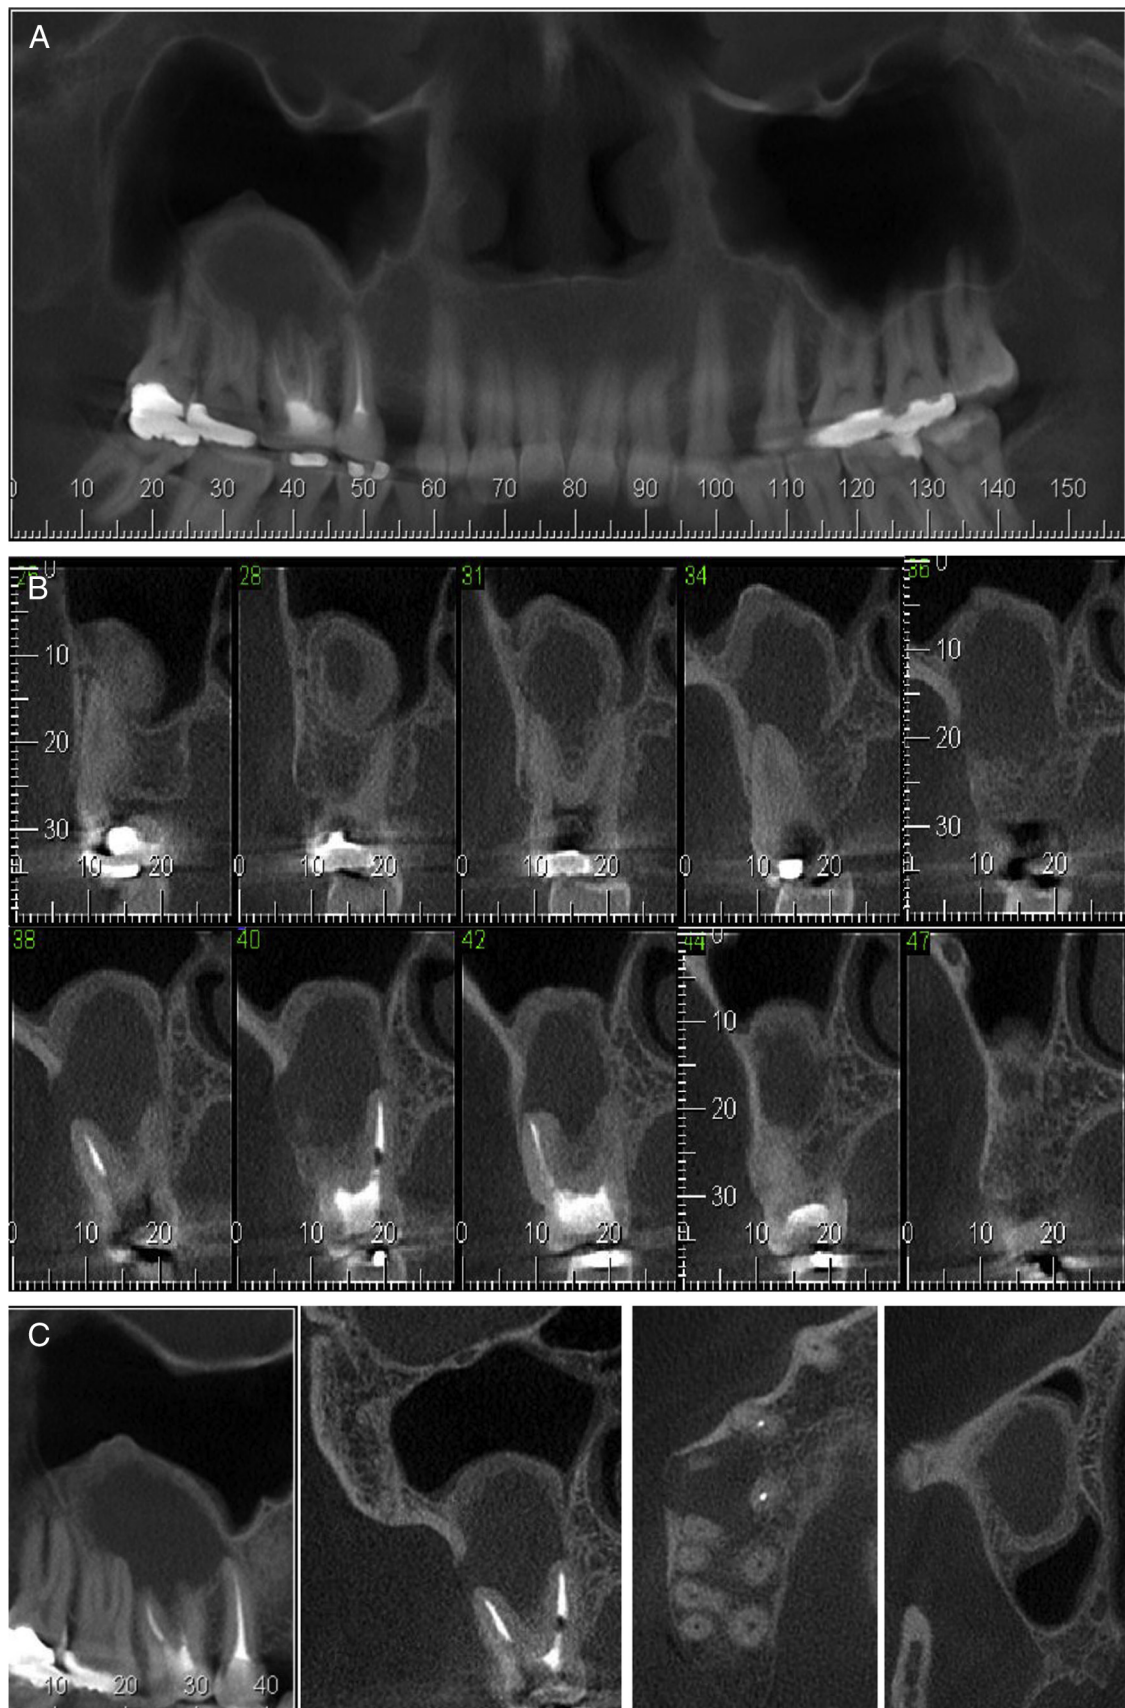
(A–C) CBCT scan shows root canal treatment of tooth #3 with a large periapical lesion surrounded by a thick layer of hyperdense bone that appears to be reactionary osteogenesis; internal margins are irregular and some are concave, which suggests the absence of growth under pressure.
